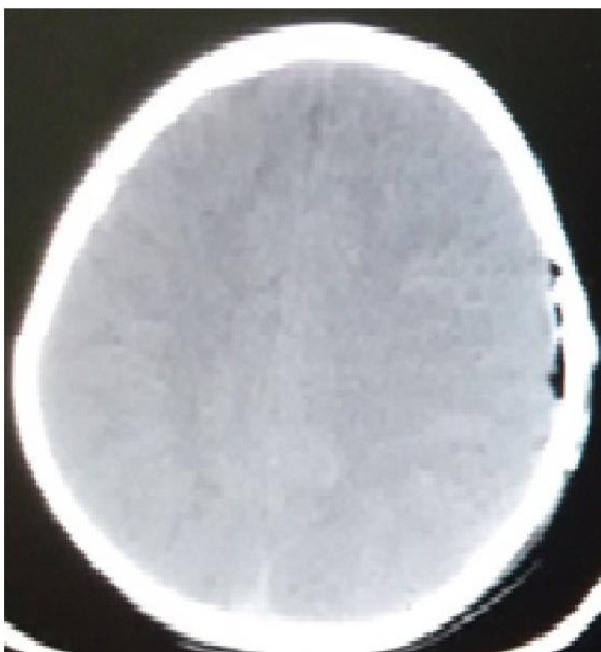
Non contrast computed tomography after six months following surgical evacuation of acute subdural hematoma.
